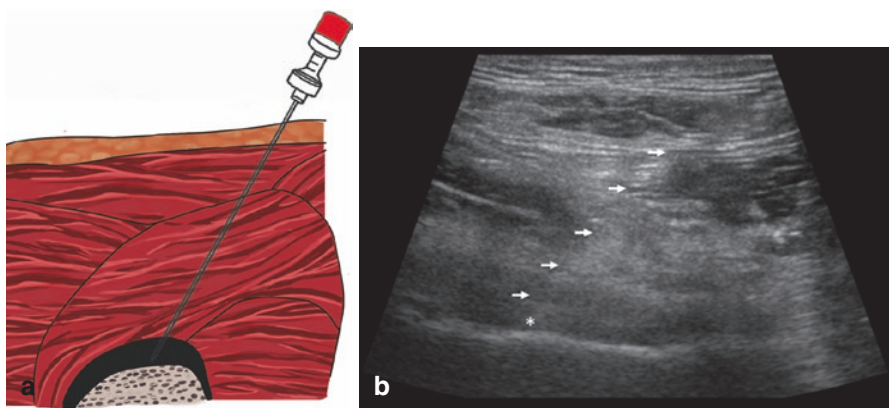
US injection technique, lateral approach. (a) The needle is inserted approximately 2 cm from the distal part of the probe with an angle of about 45° to the horizontal skin plane having as a target the head-neck junction. (b) Sonographic visualization: asterisk, intra-articular target point for injection, at the level of the head and neck junction; arrows, needle (note that the needle is not well visualized: ultrasound beam allows for optimal visualization when the surface of the probe is parallel to the needle, and therefore beam direction perpendicular; this becomes more relevant for thinner needles and lower ultrasound frequencies)
